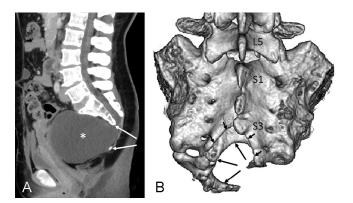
(A) Sagittal CT scan showing a well-demarcated hypodense mass in the presacral region (asterisk) 12×10 cm in maximal dimension accompanying chronic-appearing, well-marginated bony defects in the ventral sacrum (arrows). (B) Dorsal view from a 3-dimensional CT scan showing a spina bifida below the S3 level (short arrows) and the scimitar outline in the sacrum (long arrows). CT, computed tomography.
